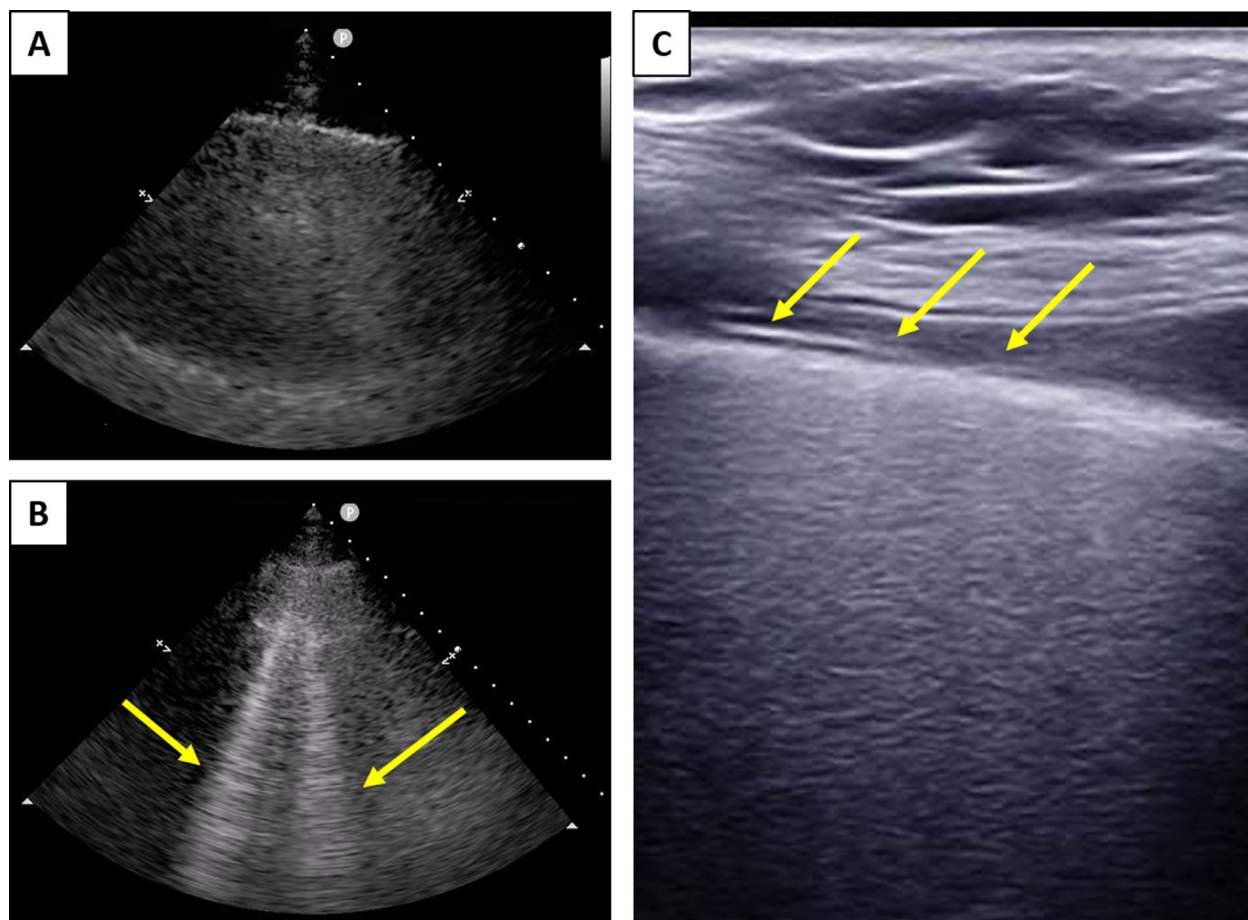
(A) Lung ultrasound demonstrates area of consolidation prior to placing the patient in the prone position. Consolidation in a nonaerated lung, which results in a significant shunt. (B) Lung ultrasound after placing the patient in the prone position demonstrates significant “B lines” (arrows) consistent with acute respiratory distress syndrome, however, with improved aeration. Clinically, the patient’s oxygenation improved as well after proning. (C) Linear probe demonstrates a thickened pleural line (arrows).
